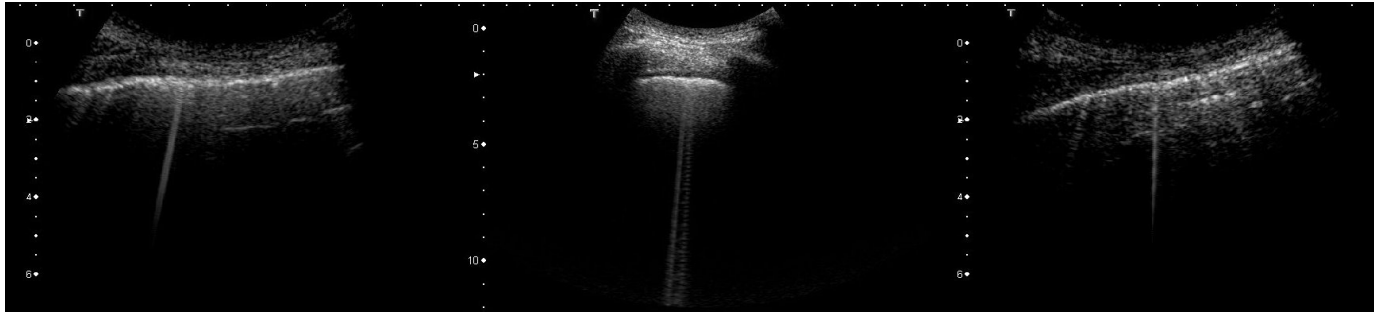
Left: Example of a nonmodulated B line. Center and Right: Typical examples of modulated B lines which are commonly observed on lung ultrasound images.
